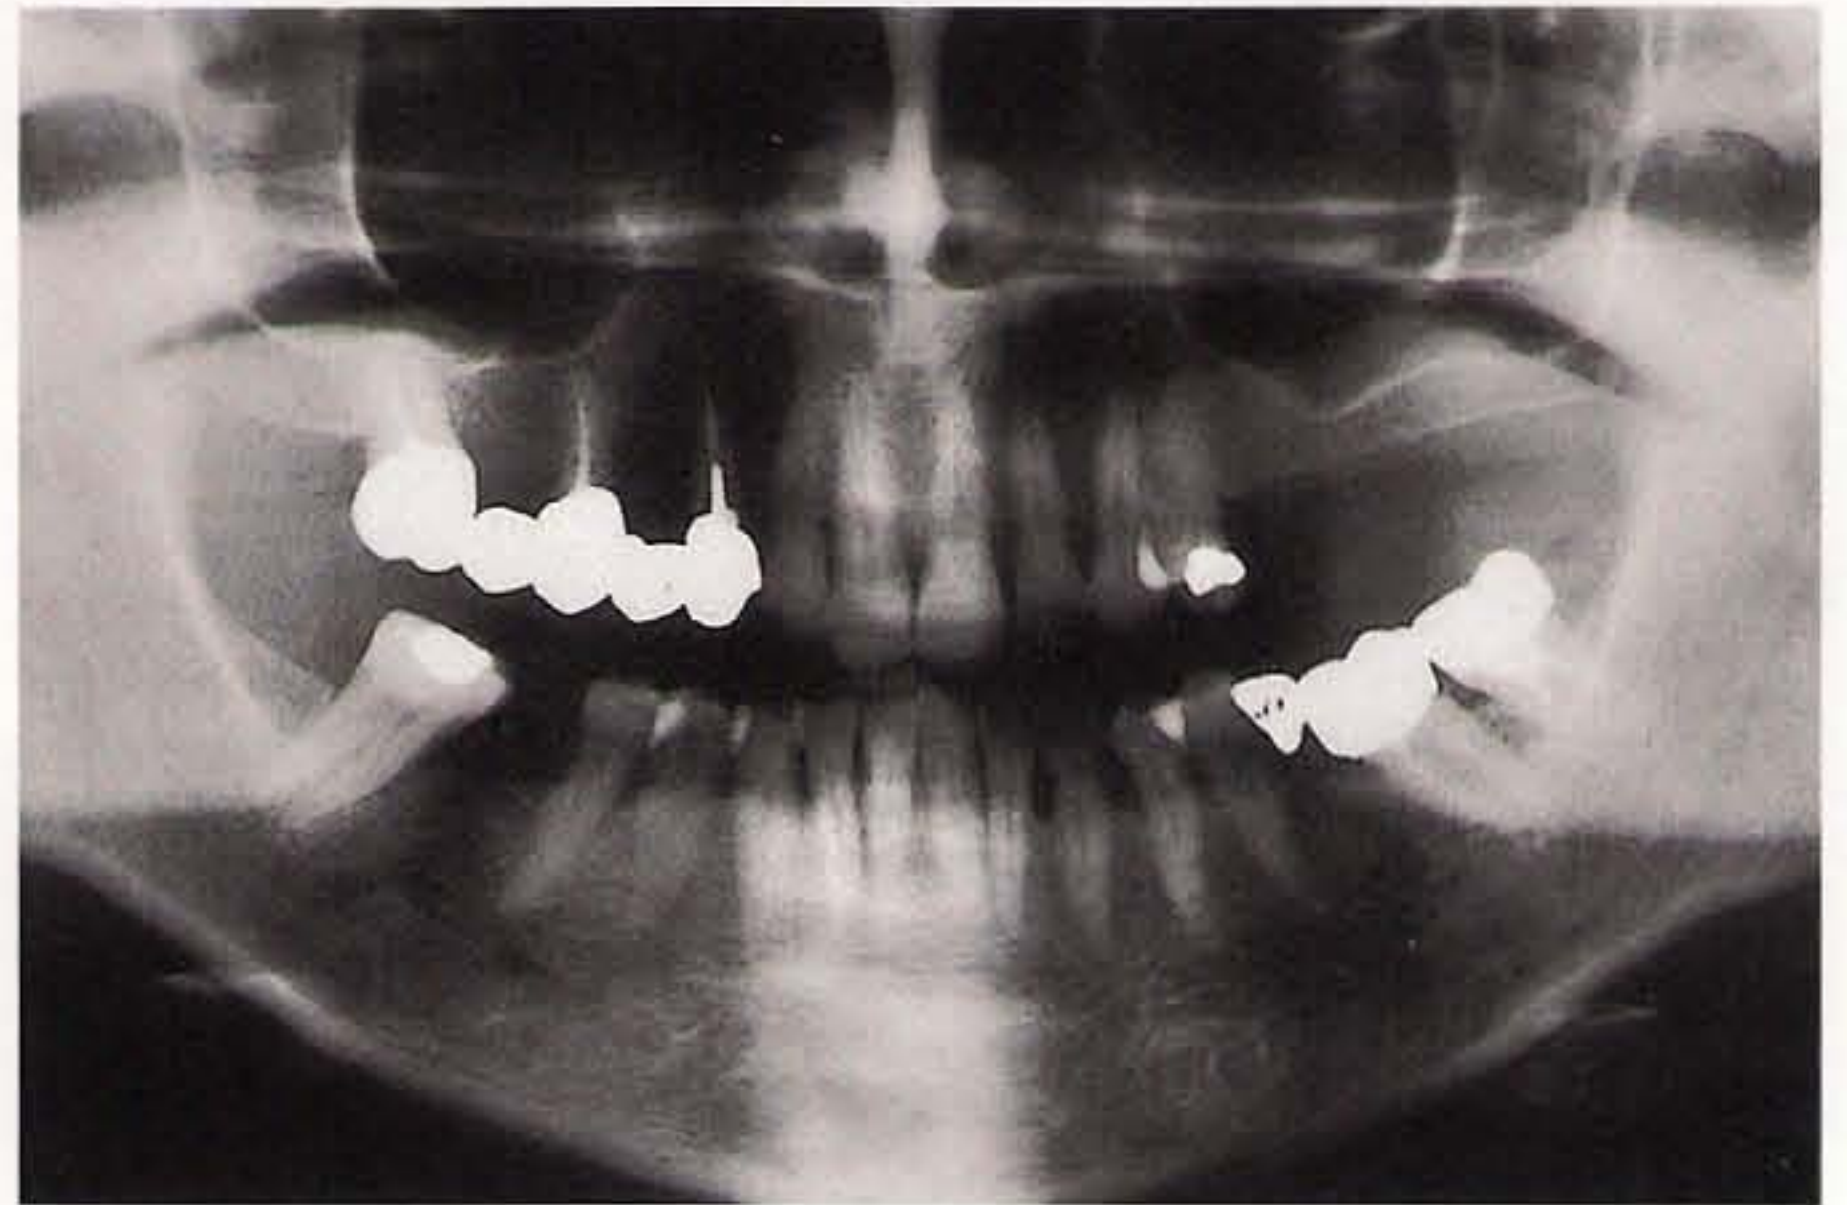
Panoramic radiograph of a posteriorly edentulous maxilla with insufficient basal bone.
